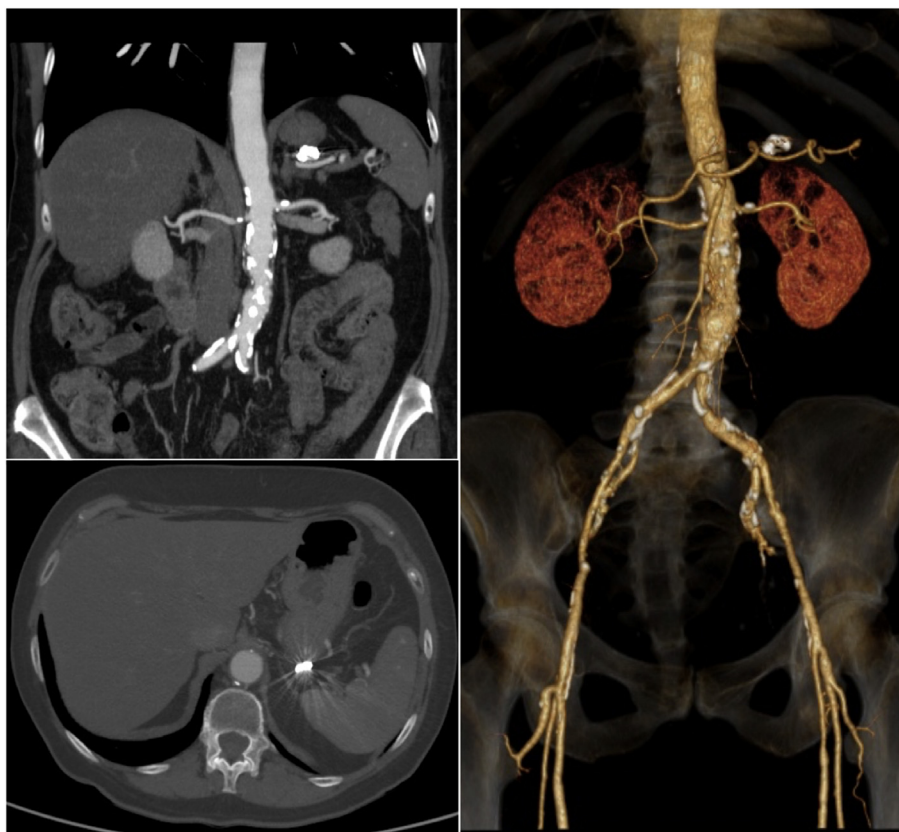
Computed tomography angiography demonstrating exclusion of the posterior gastric artery aneurysm.
